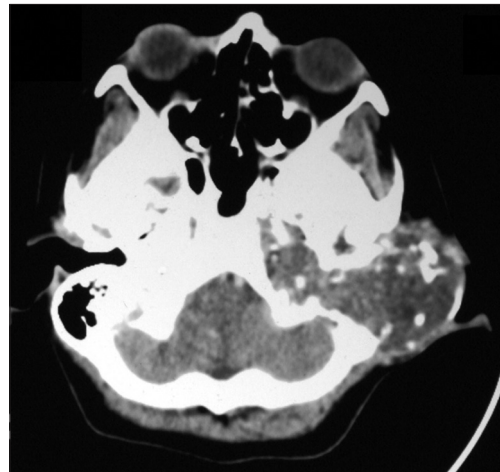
CT scan of the adenoid cystic carcinoma patient showing destruction of the petrous bone with involvement of the external ear
